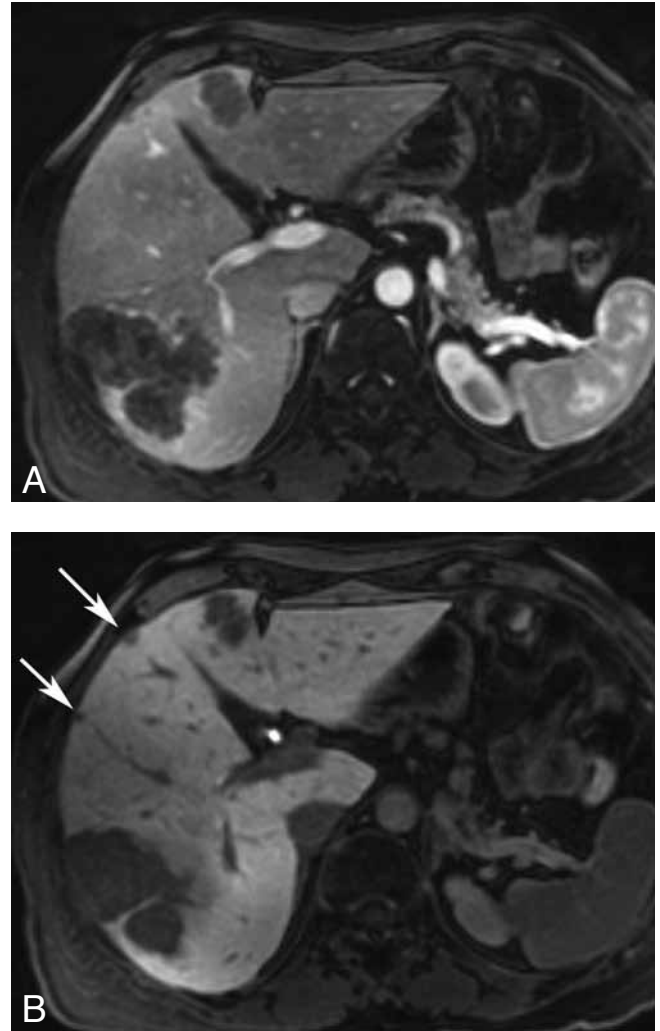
The value of liver-specific contrast agents. A. Gadoteric acid-enhanced MRI in the venous phase shows 2 liver metastases. B. The delayed-phase image shows two additional small subcapsular lesions (arrows) not well seen in the venous phase.
